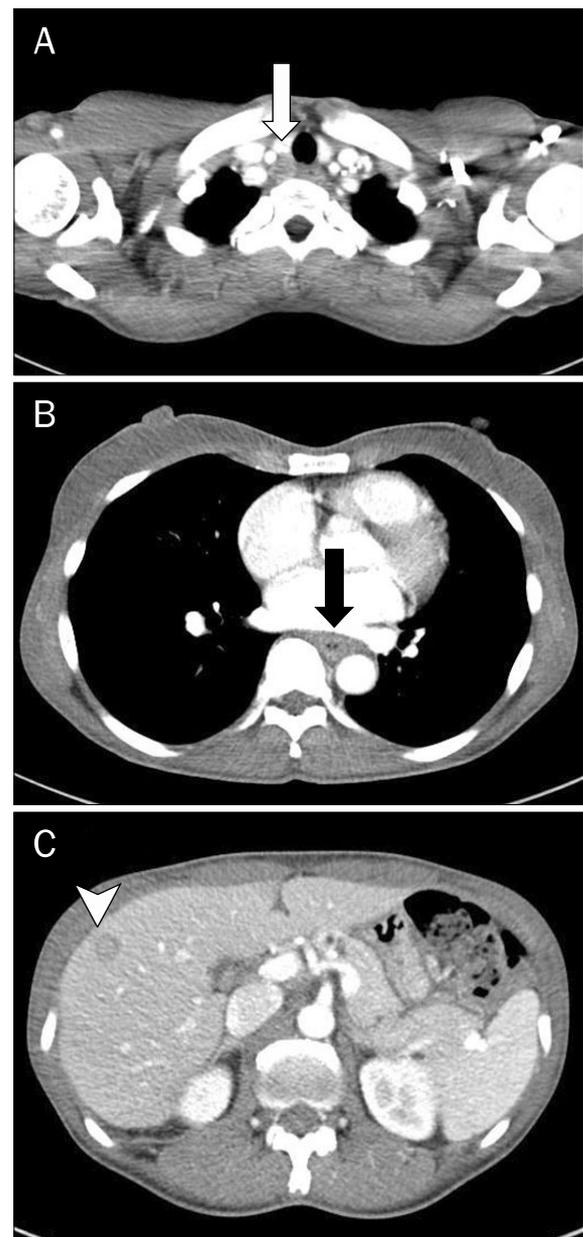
A computed tomography scan showed (A) enlarged superior mediastinal lymph nodes (white arrow) of (B) an esophageal tumor (black arrow) with (C) a ~ 1.2 -cm-sized hypoattenuated lesion (arrowhead) in S5 of the liver.
